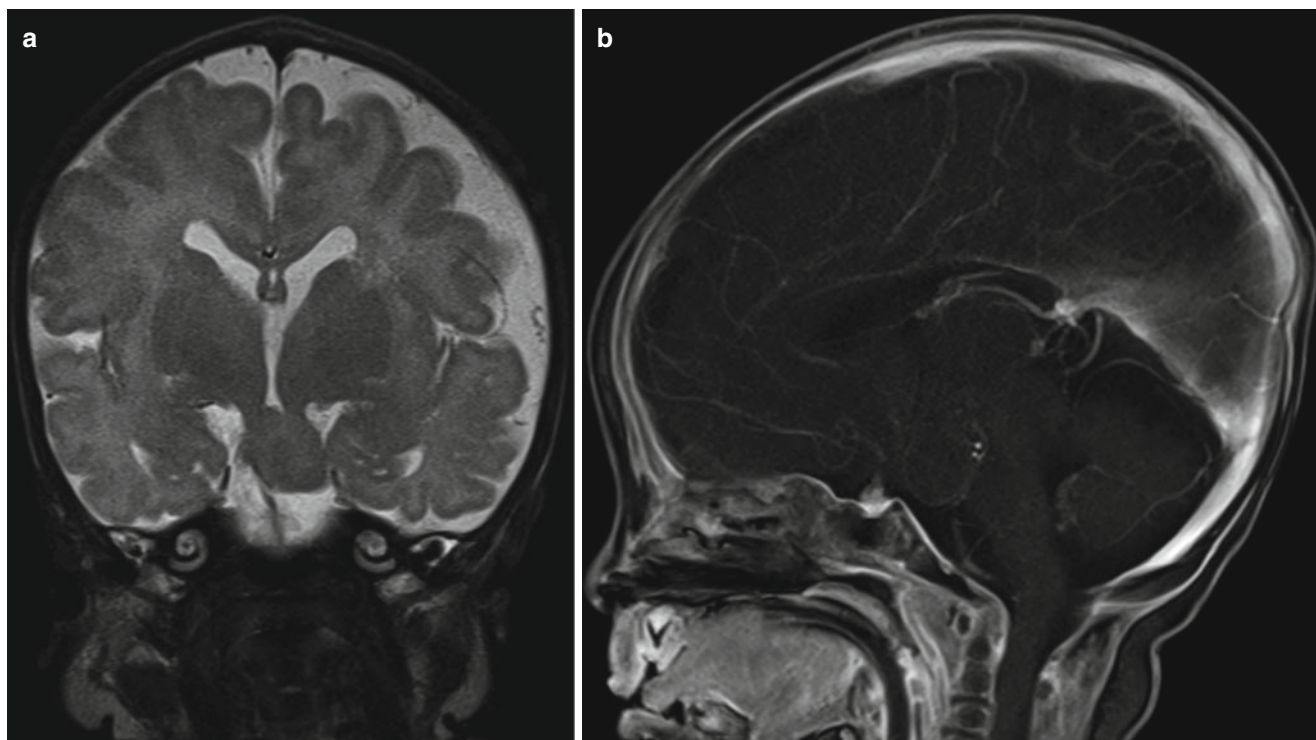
Central precocious puberty in 5-year-old girl with vaginal bleeding. (a) T2-weighted coronal MR image shows focal mass at tuber cinereum. (b) Contrast-enhanced sagittal T1-weighted MR image shows no contrast enhancement of mass in tuber cinereum
